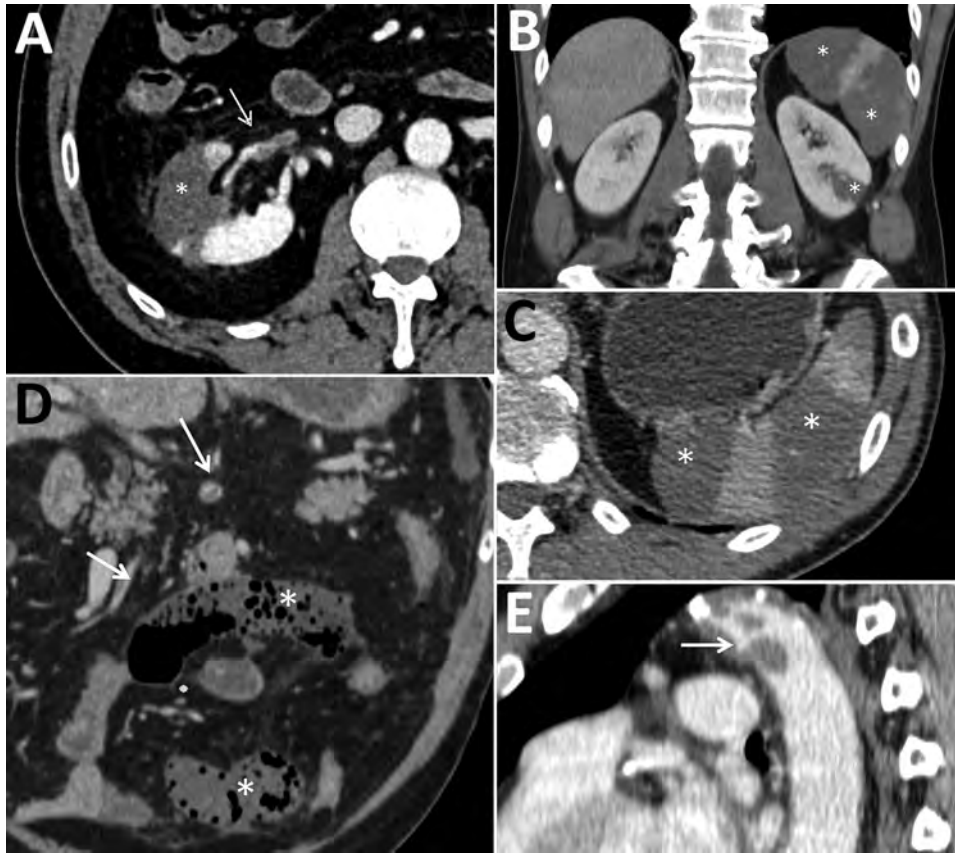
Abdominal contrast-enhanced computed tomography scans of 3 coronavirus disease patients with abdominal visceral infarction, Italy. A) Patient 1 (axial view) showing intraarterial thrombi in the renal artery (arrow) and kidney and splenic infarctions (asterisk), seen as large wedge-shaped hypodense parenchymal areas. B, C) Patient 2 (B, coronal view; C, axial view) showing kidney and splenic infarctions (asterisks), seen as large wedge-shaped hypodense parenchymal areas. D, E) Patient 3 (D, coronal view; E, sagittal view), showing intraarterial thrombi in the superior mesenteric artery and its branches (arrows in D) and thoracic descending aorta (arrow in E), as well as small bowel ischemia (asterisks in D), seen as small bowel loops with decreased or absent wall enhancement. In patients 1 and 2, scans did not show notable signs of atherosclerosis.
